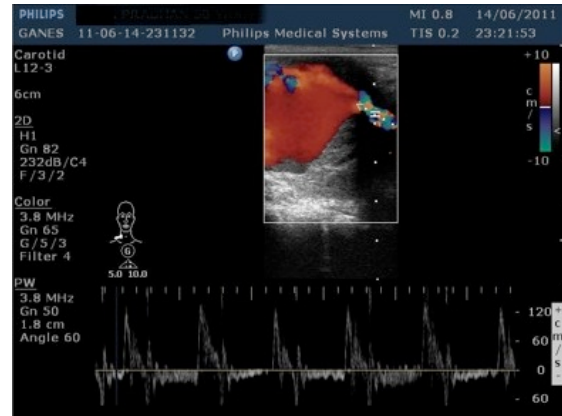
Color Duplex Sonography with spectral waveform showing partially thrombosed large pseudoaneurysm (showing yin-yang type of blood flow) involving the right CCA
